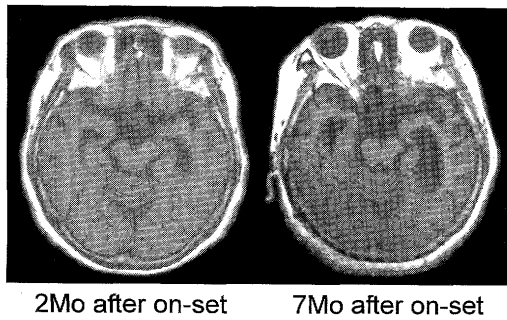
T1-weighted magnetic resonance images 2 and 7 months after onset. Rapid progression of diffuse cerebral atrophy occurred during the 5 months between images.
